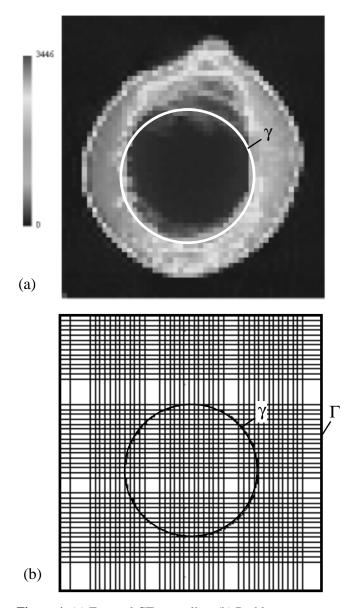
(a) Femoral CT-scan slice; (b) Problem geometry
